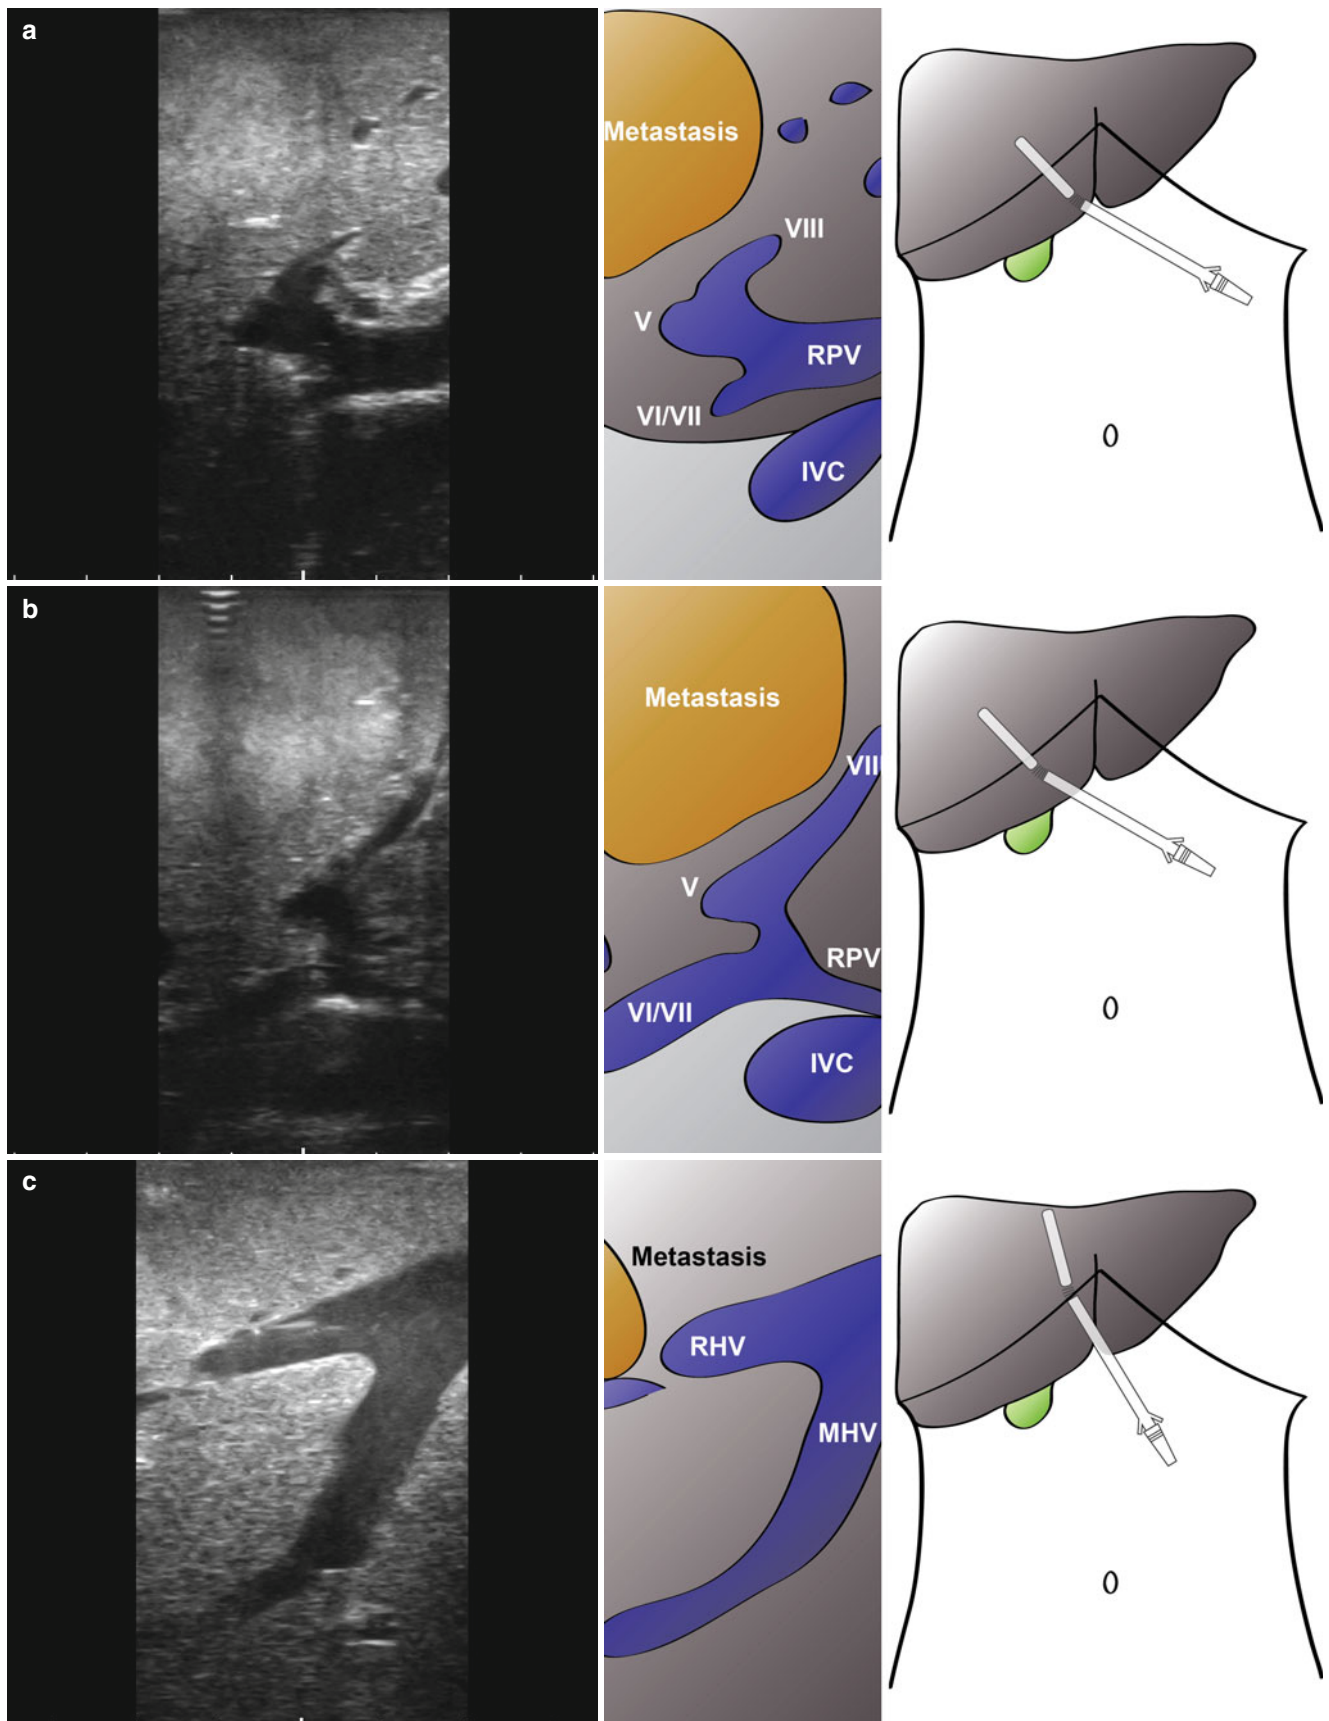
Intraoperative ultrasonography to determine relationship of large colorectal liver metastasis to vascular structures. A local resection was being considered, but ultrasonography clearly shows the tumour abutting the segment VIII pedicle (a, b, Video 10.1) with no resection margin
